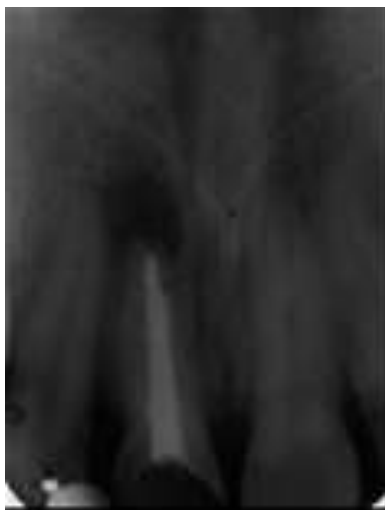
Obturated radiograph
